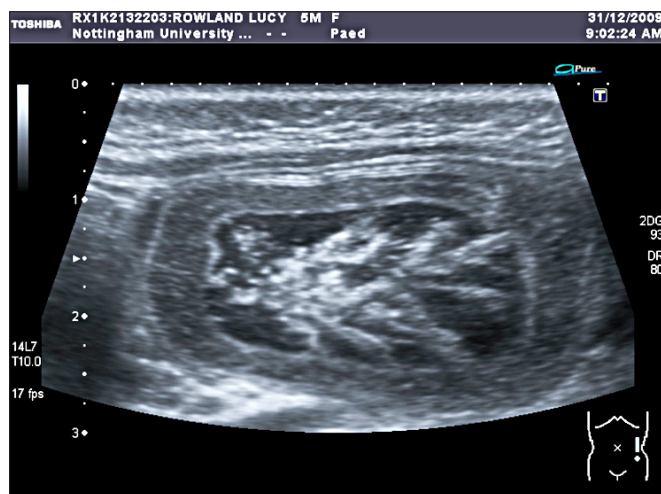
Donut sign characteristic for Intussusception with an abdominal ultrasound
